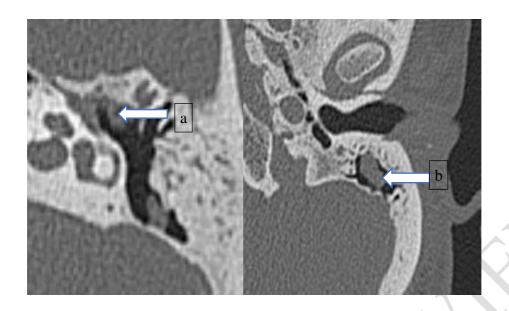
CT Scan with left sided areas of opacification (a-attic and b-mastoid tip)
